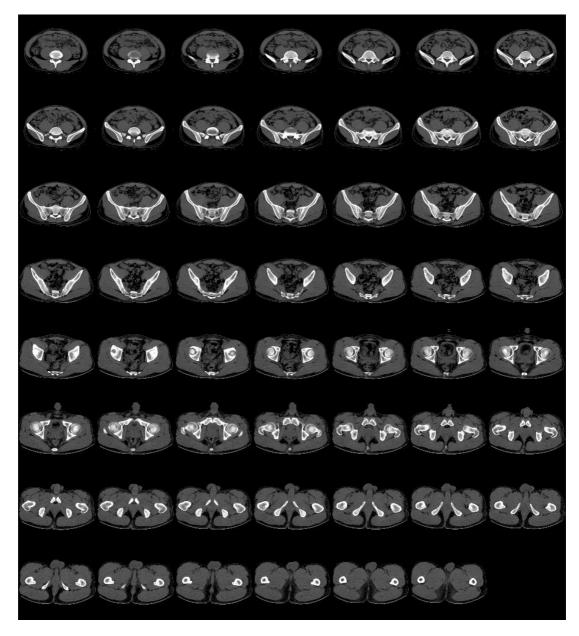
Series of 55 CT image ordered from left to right and from top to bottom
